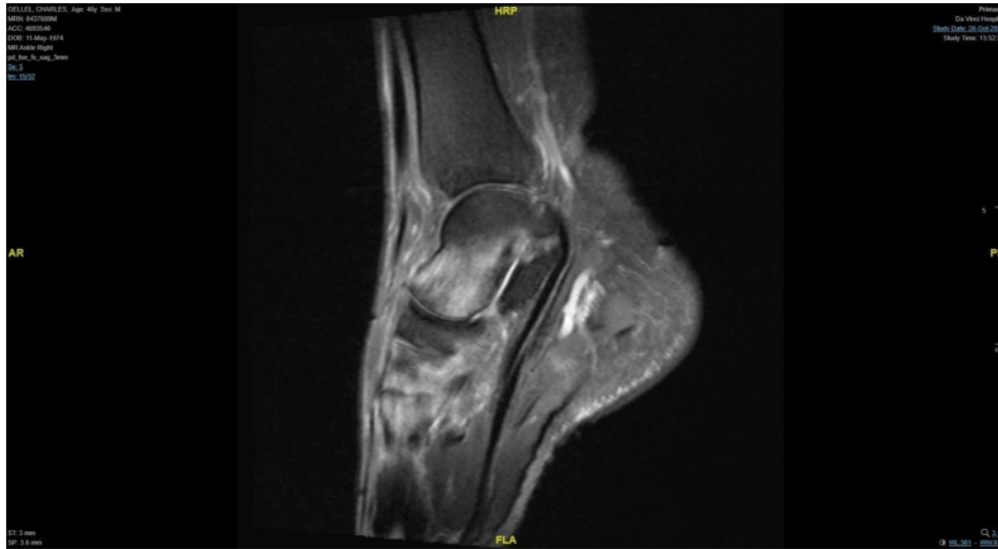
Sagittal section from MRI of the ankle showing bone marrow oedema of the talar head.
